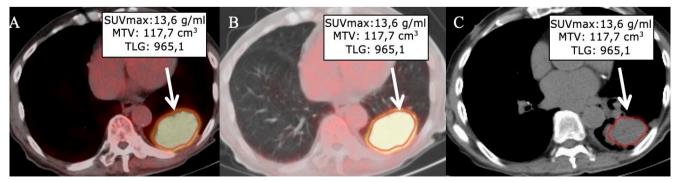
Pretreatment ¹⁸F-FDG PET/CT images of a patient with NSCLC without EGFR mutation, demonstration of the SUVmax, MTV, and TLG values derived from the primary lung tumor (arrow) on the axial fused images (a,b) and axial CT images (c)
